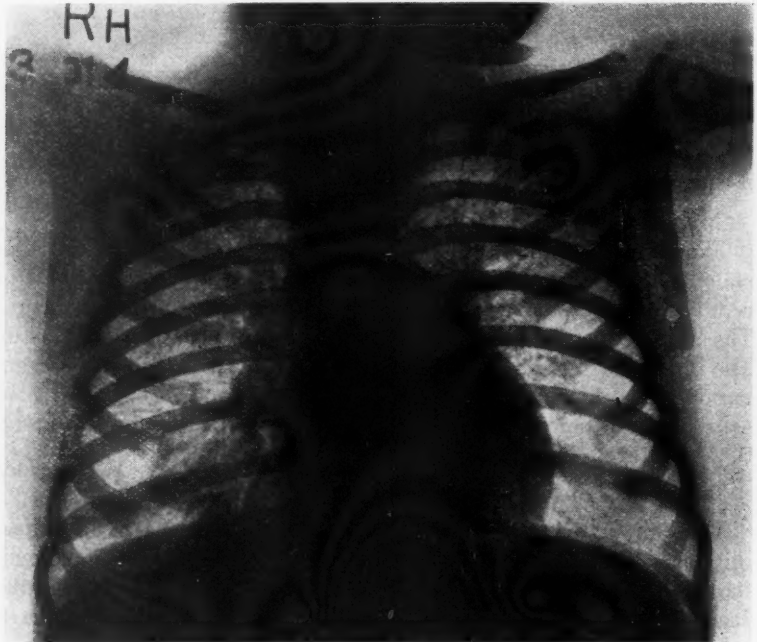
Roentgenogram showing the abscess cleared following removal of peanut.
